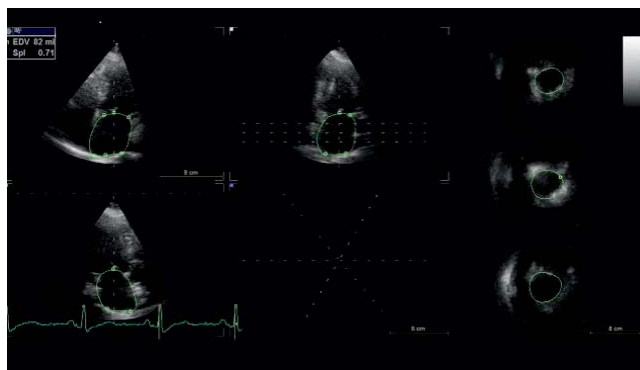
3D echocardiographic evaluation of left atrium-endocardial border in the 2D cross-sections.
